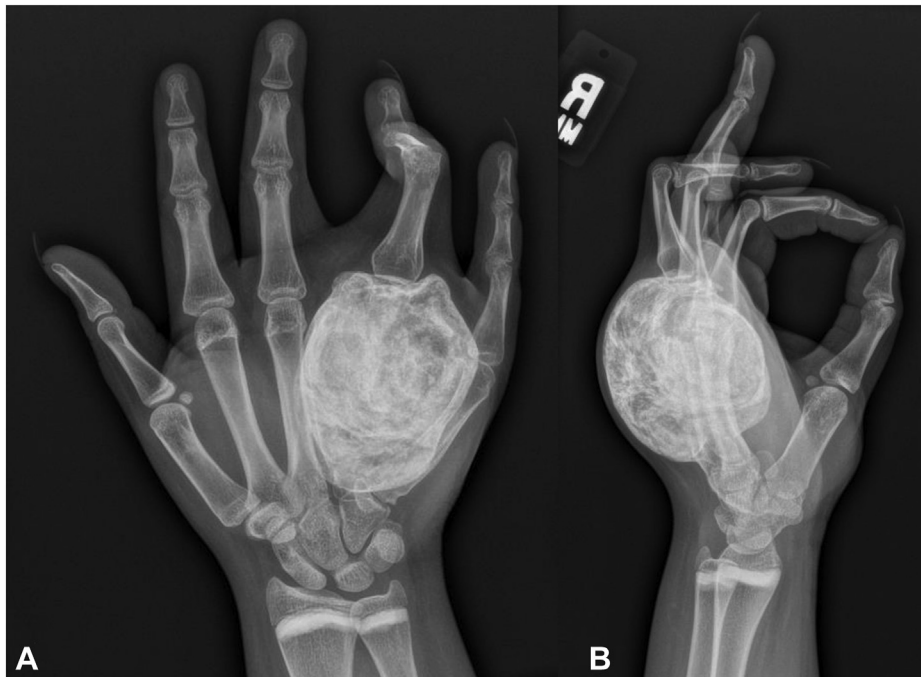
Posteroanterior and lateral radiographs after 12 months of denosumab treatment with interval development of lesional calcifications and defined border measuring $6.3 \times 5.4 \times 5.6$ cm.
